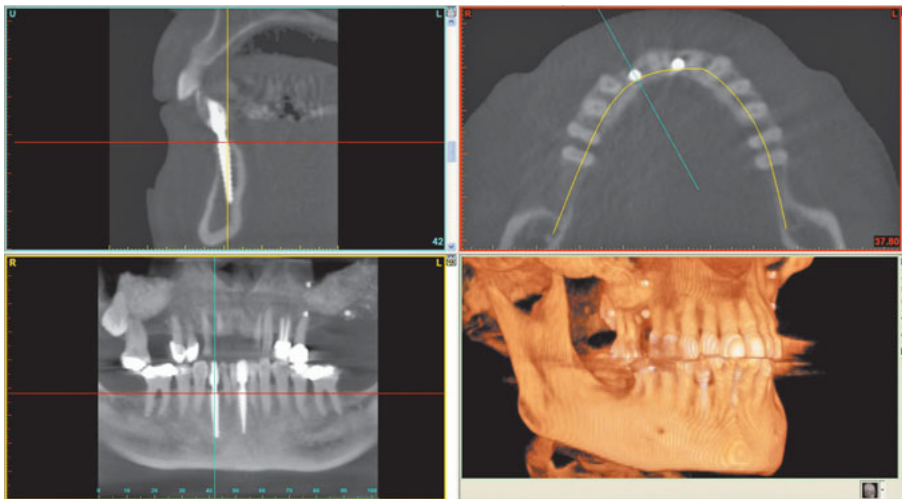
CBCT after 1 year and before the implant placement in the maxilla.
